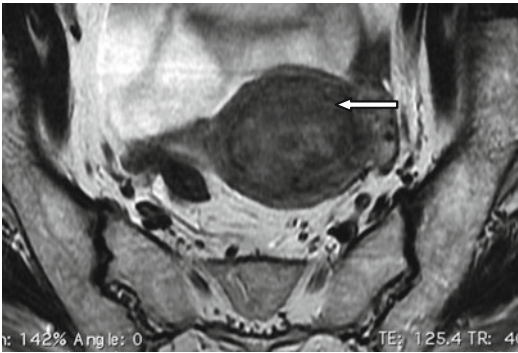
Axial T2 weighted image with history of postmenopausal bleed; T2 axial MRI showing mass filling the endometrial cavity (*straight arrow*). Poor tumor to myometrial differentiation is noted, making accurate assessment of myometrial infiltration difficult
